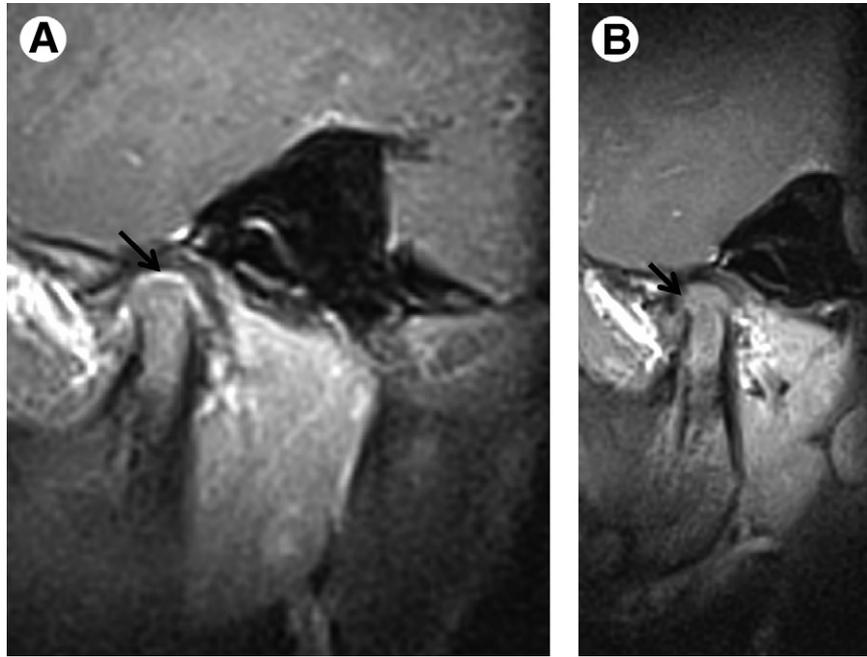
T1-weighted fat-saturated sagittal images after gadolinium administration display synovial enhancement (arrow) in the left temporomandibular joint *A*, before intra-articular corticosteroid injection and *B*, resolution after intra-articular corticosteroid injection. *B*, An erosion of the condylar head is present (arrow).
